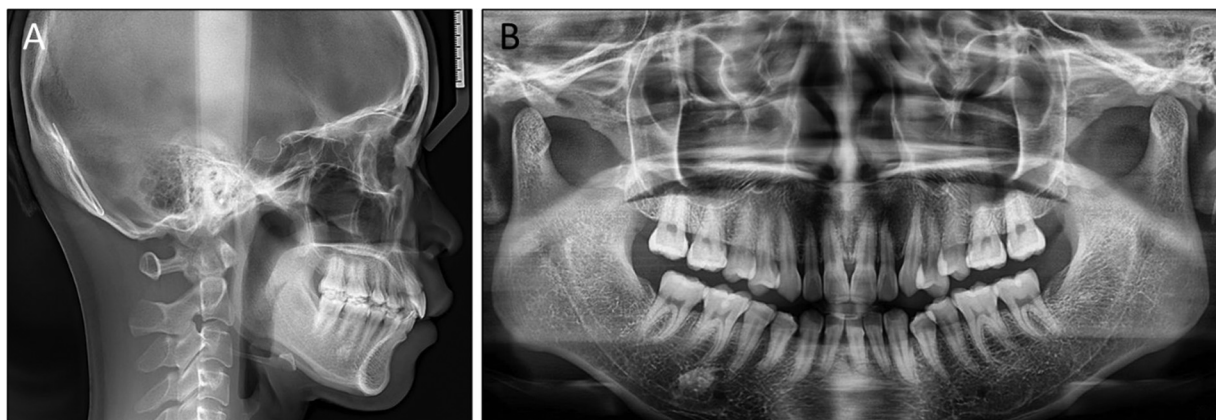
Pretreatment radiographs: (A) lateral cephalometric radiograph and (B) panoramic radiograph.
